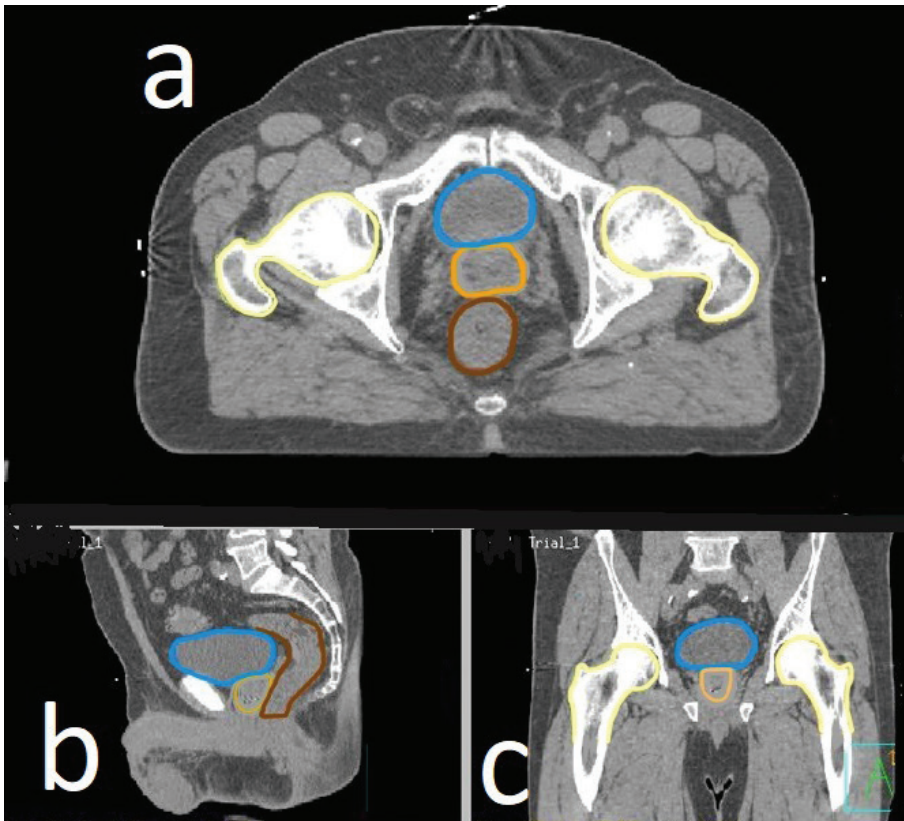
Computed tomography images (a, b and c) are a male pelvis, showing how structures are outlined in preparation for conversion into a video. Blue = bladder, beige = prostate, brown = bowel, yellow = femur bones.
